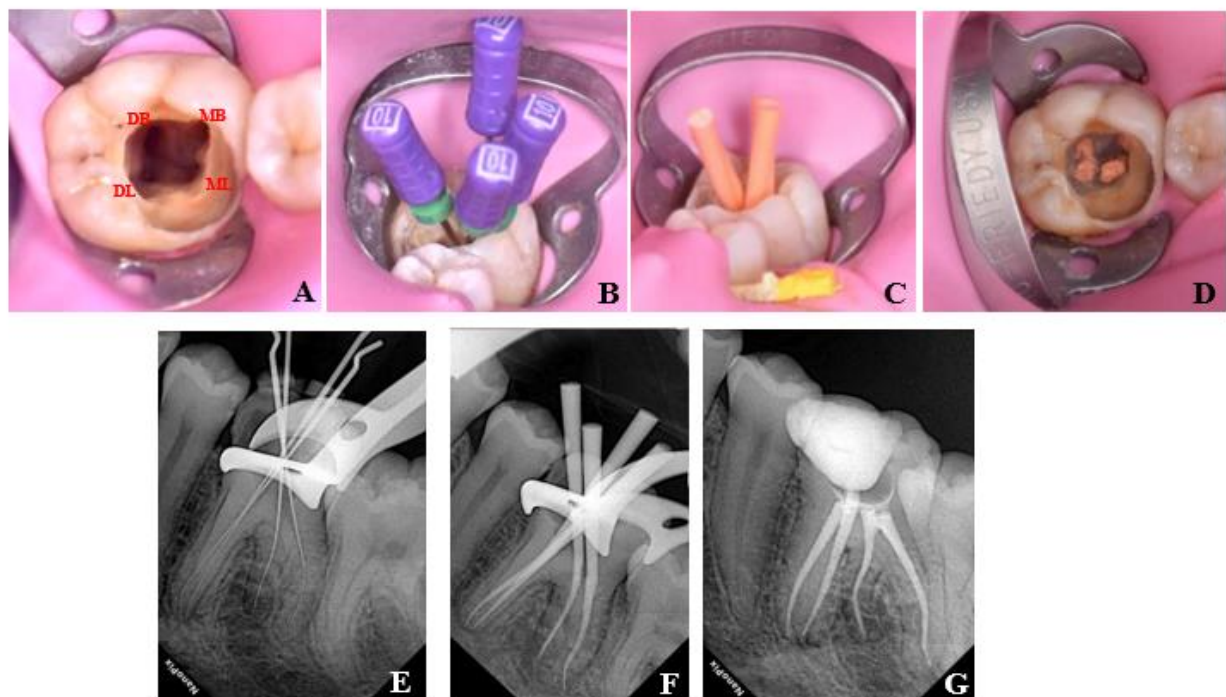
(A) Access cavity preparation of mandibular left first molar (tooth 36) showing four canal orifices: mesiobuccal (MB), mesiolingual (ML), distobuccal (DB), and distolingual (DL) corresponding to radix entomolaris; (B) Working length determination using #10 K-files in all canals; (C) Master cone trial with gutta-percha cones adapted to the prepared canals; (D) Obturation for all canals; (E) Radiograph confirming working length determination; (F) Radiograph confirming master cone adaptation before obturation; (G) Radiograph showing obturation of all four canal
